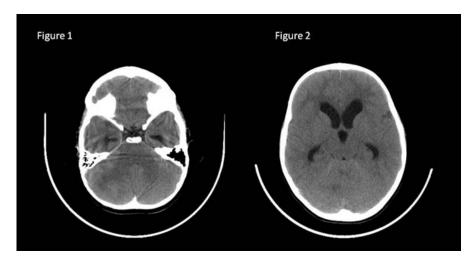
CT scans on admission showing low-density areas in the bilateral cerebellar hemispheres and findings of obstructive hydrocephalus.
